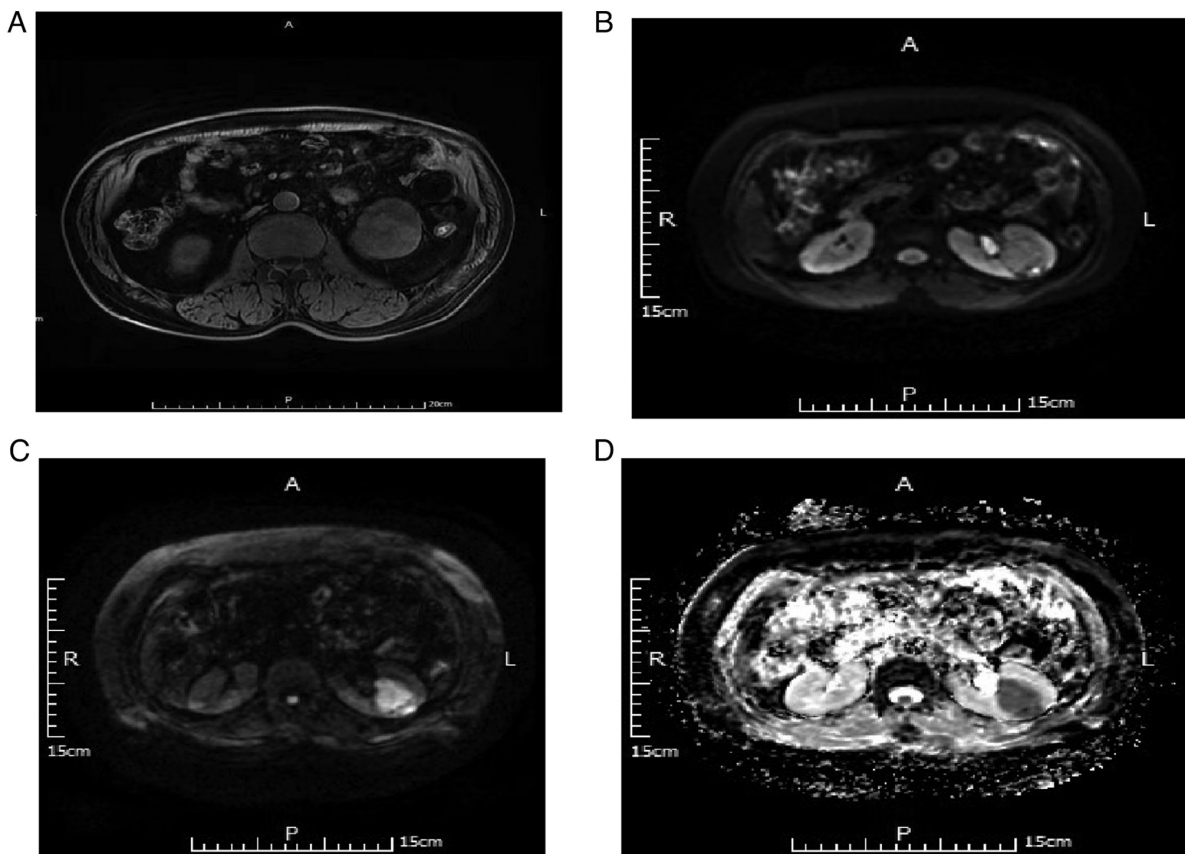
MRI scans of a 56-year-old male with pathologically confirmed chromophobe cell carcinoma of the left kidney. (A) T1WI, left renal tumor with low signal. (B) DWI B=50, left renal tumor with low signal. (C) DWI B=800, left renal tumor with obvious high signal. (D) Apparent diffusion coefficient with obviously low signal. DWI, diffusion-weighted imaging.
